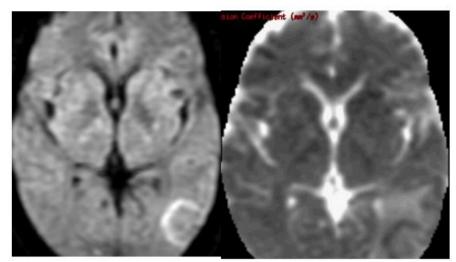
DWI(A) and corresponding ADC image shows diffusion retriction at the advancing end of the lesion in a known case of PML. PML-Progressive multifocal leukoencehalopathy.
